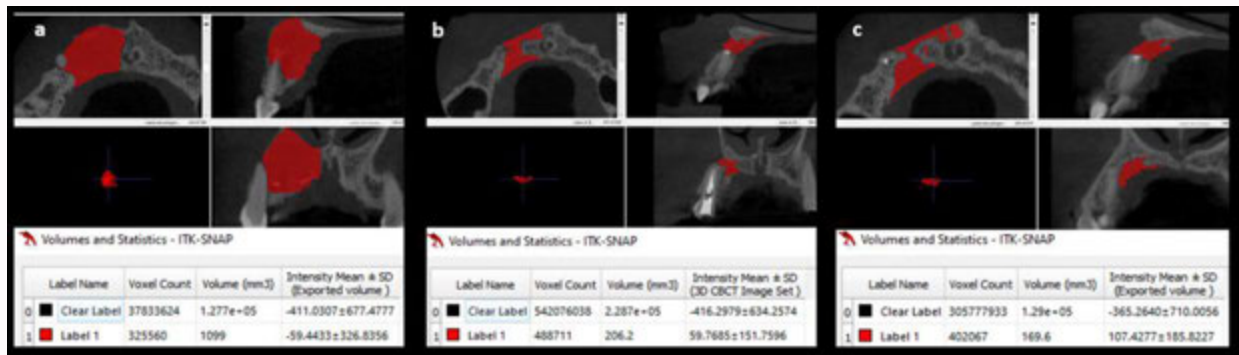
Case 3. a) Pre-operative CBCT Volumetric analysis using ITK-SNAP Software, b) First follow-up CBCT Volumetric analysis using ITK-SNAP Software, c) Second follow-up CBCT Volumetric analysis using ITK-SNAP Software.
